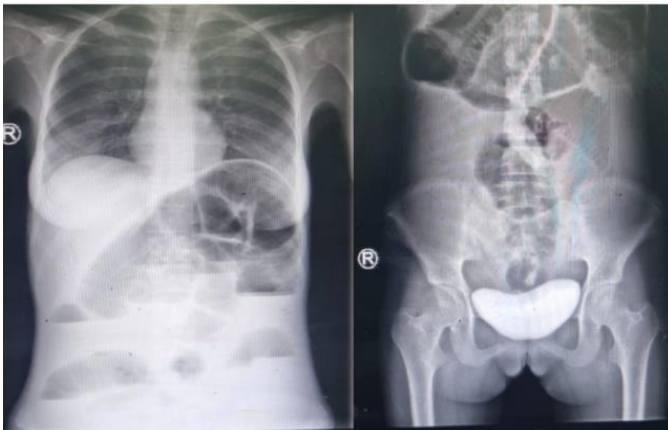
Plain X-Ray Abdomen Showing Opacity Air Fluid Levels.
